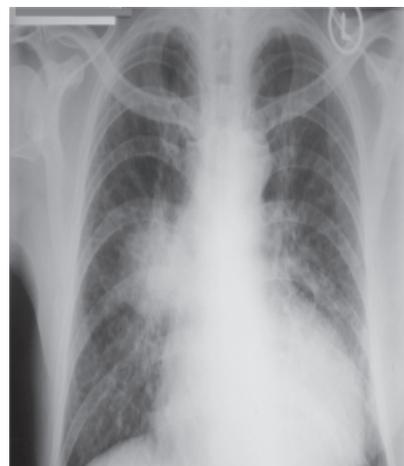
Chest radiograph taken at time of admission
